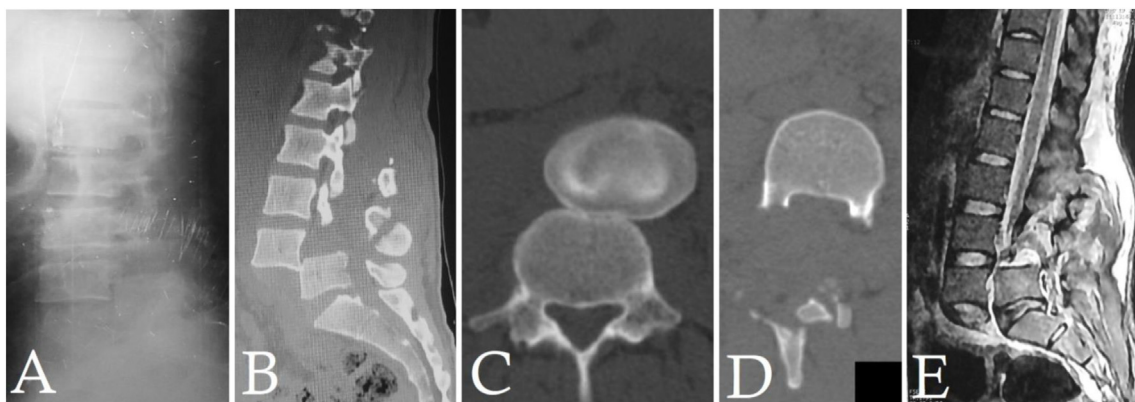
(A) Preoperative lateral view X-ray showing complete fracture-dislocation of L4-5, (B) Preoperative sagittal CT reformat showing complete displacement of L4 in front of L5, (C) Preoperative axial CT image showing the characteristic 'double sun' appearance, (D) Preoperative axial CT image showing bilateral pedicular fractures of L4 separating the posterior arch of L4 from the vertebral body creating space for the thecal sac, (E) Preoperative MRI sagittal image showing the increased sagging of L4 in front of L5 and the severe transition of the thecal sac.
